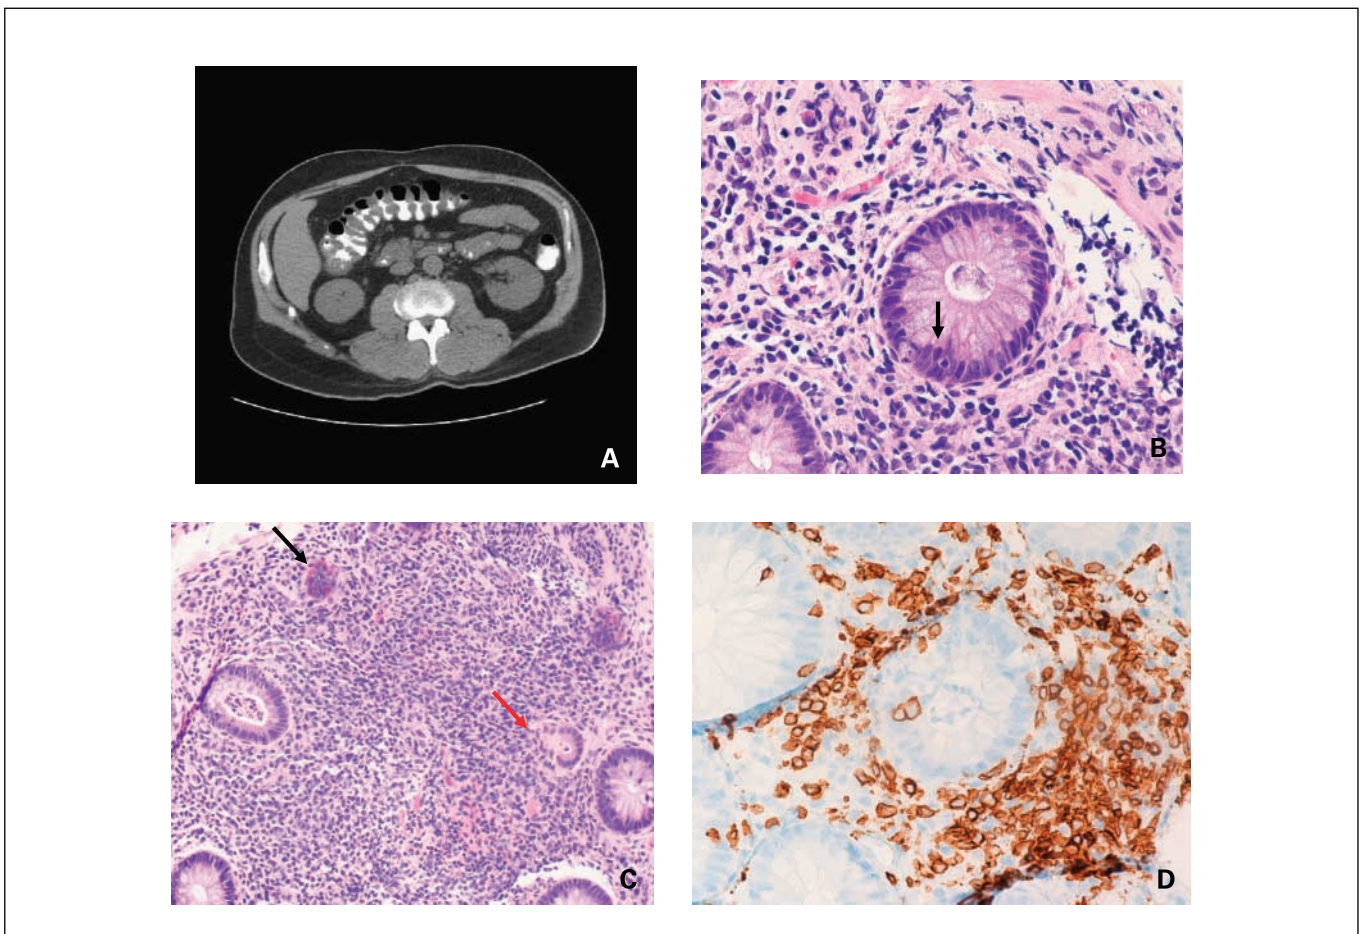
A, computed tomography scan of abdomen showing thickened bowel wall (MD11). B, crypt cell apoptosis (MD11). C, features of GVHD, including crypt lysis (red arrow) and neuroendocrine cell hyperplasia (black arrow; MD11). D, intraepithelial CD3⁺ T cells (MD11).
